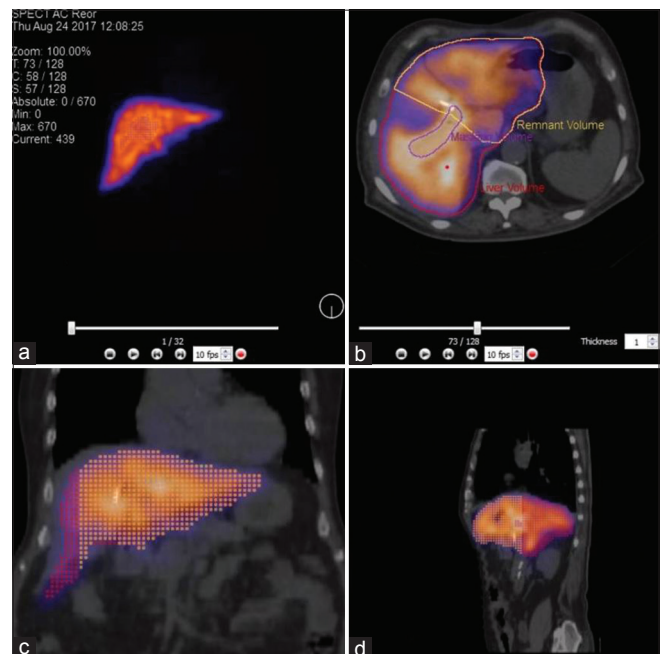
Tc-99m Mebrofenin single photon emission computed tomography-computed tomography functional volumetry. Image (a) showing maximum intensity projection. Image (b-d) showing the volume of interest for liver and remnant in axial, coronal, and sagittal view, respectively. Volume of interest on the right hepatic duct is showing average liver activity now
